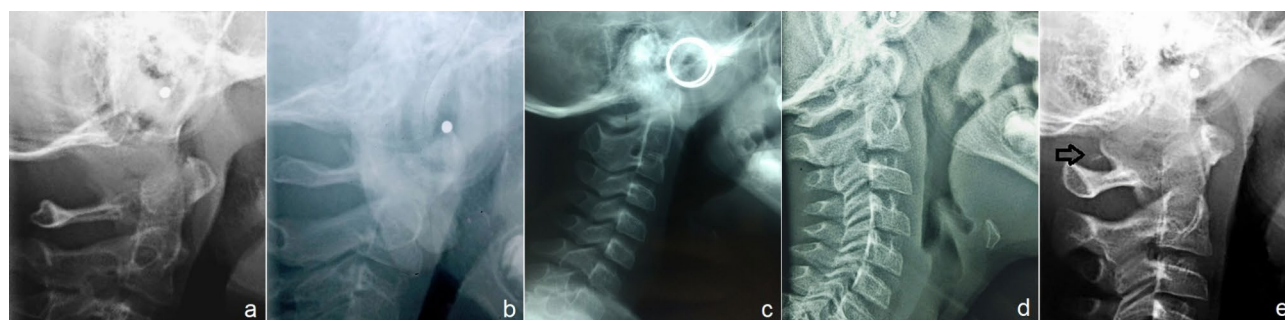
Radiographic images showing cervical vertebral anomalies: (a) spina bifida, (b) dehiscence, (c) fusion, (d) occipitalization, and (e) accessory ossicle
